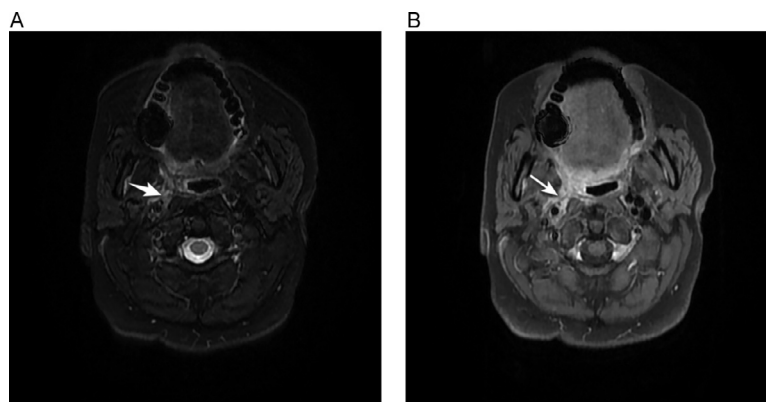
Follow-up MRI. (A) Axial T2 sequences shows slight residue of tumor. (B) Axial post contrast images shows significant regression of tumor.
